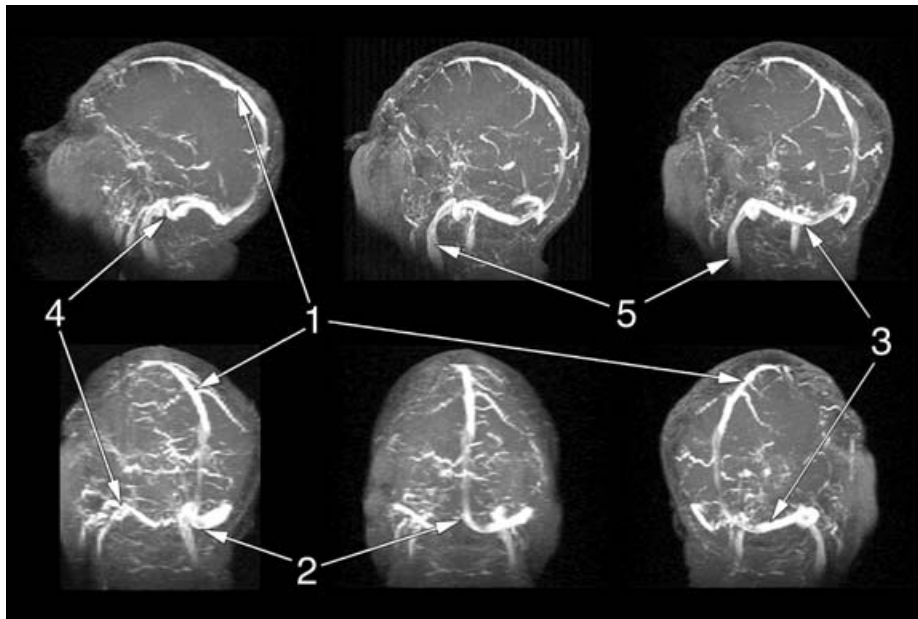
MRI venogram at select rotations. These scans label protons in one position and then identify those that have moved after a short time interval.
